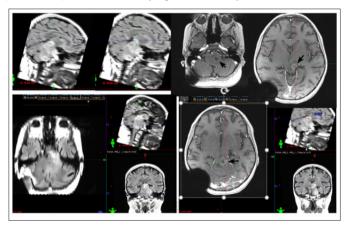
MRI/11.09.24 - MP reduction data in the size of the tumor engaging the brain stem. Structural changes and non -homogeneous contrasting are associated with a postradiation tumor necrosis. / Black arrows show tumor necrosis.
